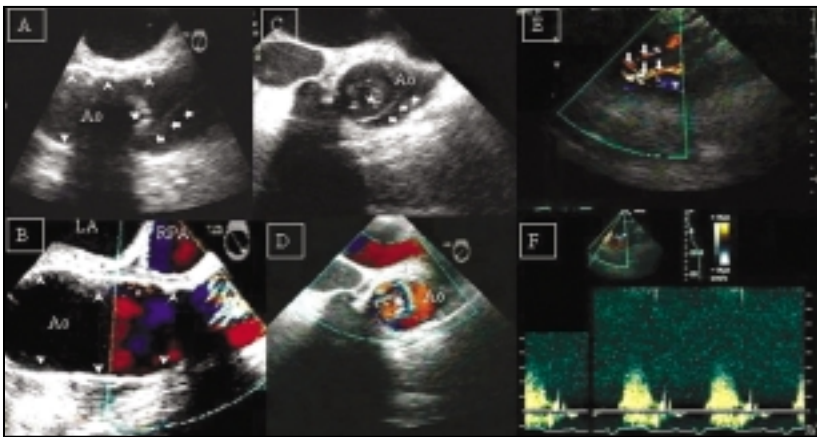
Photographs of the transesophageal echocardiogram of the aortic root, ascending aortic graft, and aortic arch obtained after the Bentall procedure in patient 2. Ascending aorta (Ao), ascending aortic graft (A and B, white arrowheads), dissection flap distal to distal aortic anastomosis (A and C, white arrows), and a centrally located circumferential flap (A and C, white star) are shown. Turbulent systolic blood flow within the circumferential flap causing opening of the flap is shown in longitudinal (B, black asterisk) and cross-sectional (D, white asterisk) views. Color Doppler image of the aortic arch and proximal great aortic vessels shows turbulent blood flow in all vessels (E, white arrows). Continuous-wave Doppler imaging revealed a gradient of 43 mm Hg across the distal ascending aorta (F).
